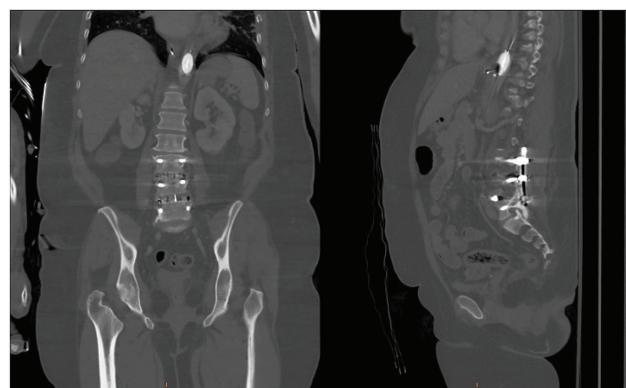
Coronal (left) and sagittal (right) views of the patient's computed tomography scan, which demonstrate positioning of the balloon in zone I just above the diaphragm.
